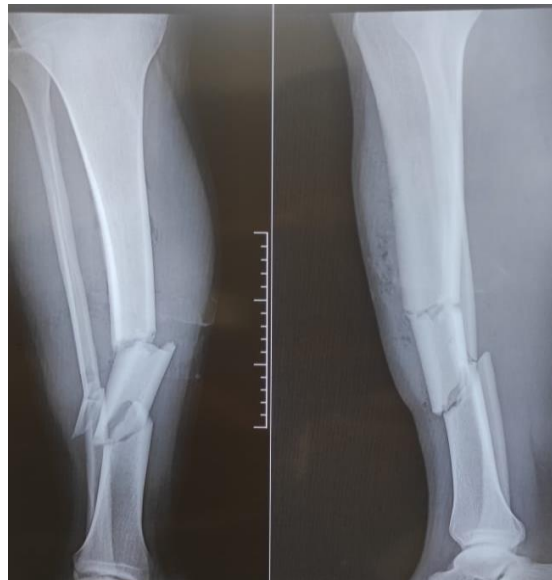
Anteroposterior and lateral leg X-ray at admission
